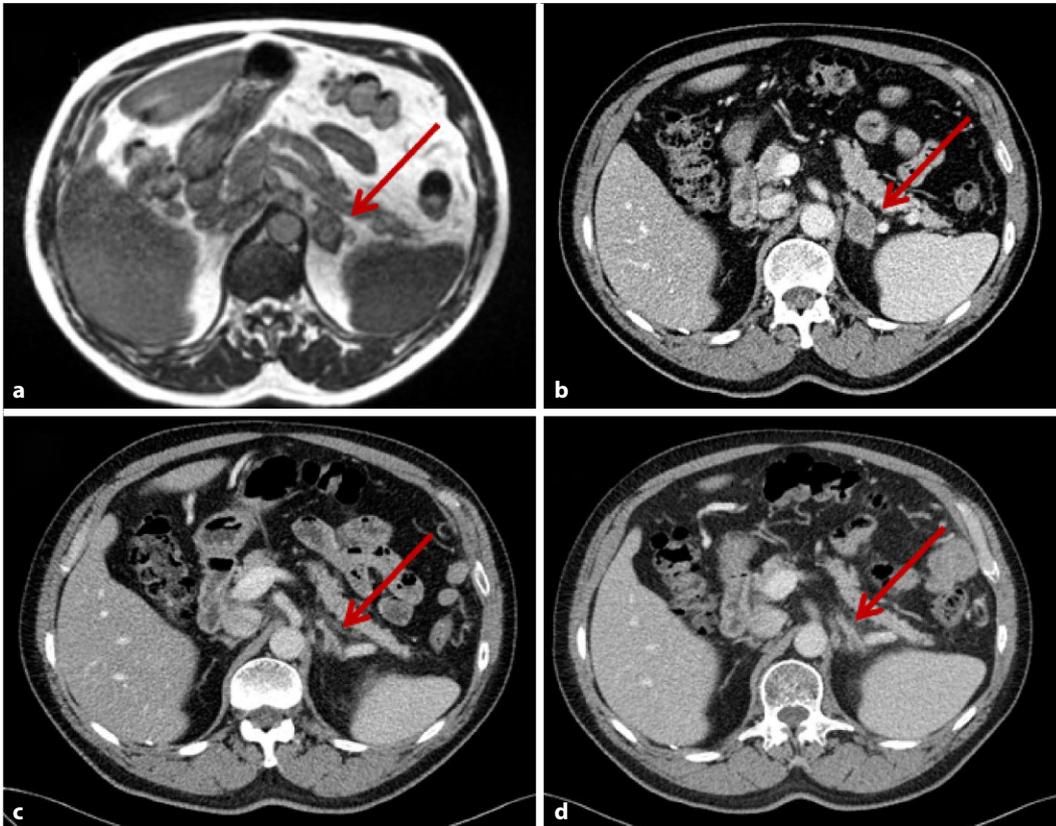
◀ Left adrenal metastasis (red arrow): a TrueFISP at the MR-Linac for treatment planning; b contrast-enhanced computed tomography (CT) scan for treatment planning; c and d contrast-enhanced CT scan 3 months and 6 months after MR-guided radiotherapy of the liver metastasis
